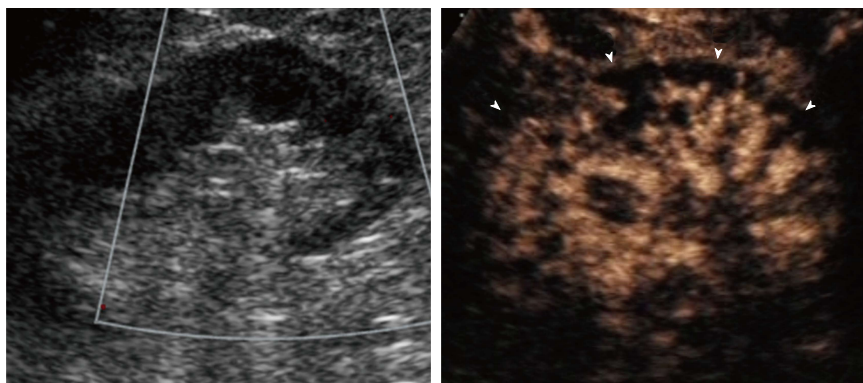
Patient with grade III chronic renal failure developing acute renal failure after Endovascular aortic repair. A: Color Doppler ultrasound showed avascular kidney; B: Contrast enhanced ultrasound showed enhancing hilar vessels and lack of enhancement of large portions of the cortex (arrowheads) consistent with acute cortical necrosis. The contralateral kidney was normal (not shown).
